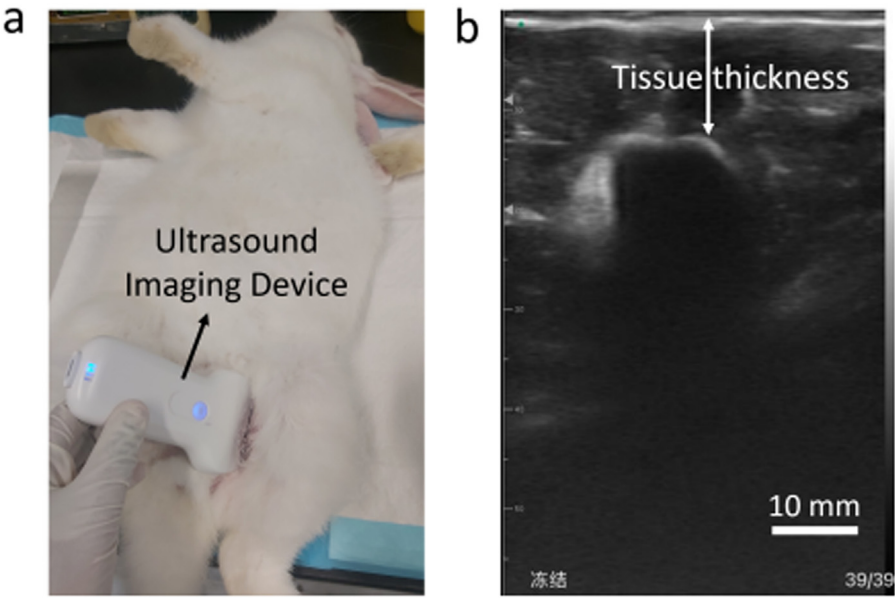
Ultrasonography for the measurement of tissue thickness. (a) Position of the rabbit for measurement of soft tissue thickness. (b) Recorded image showing the thickness of the soft tissue.
